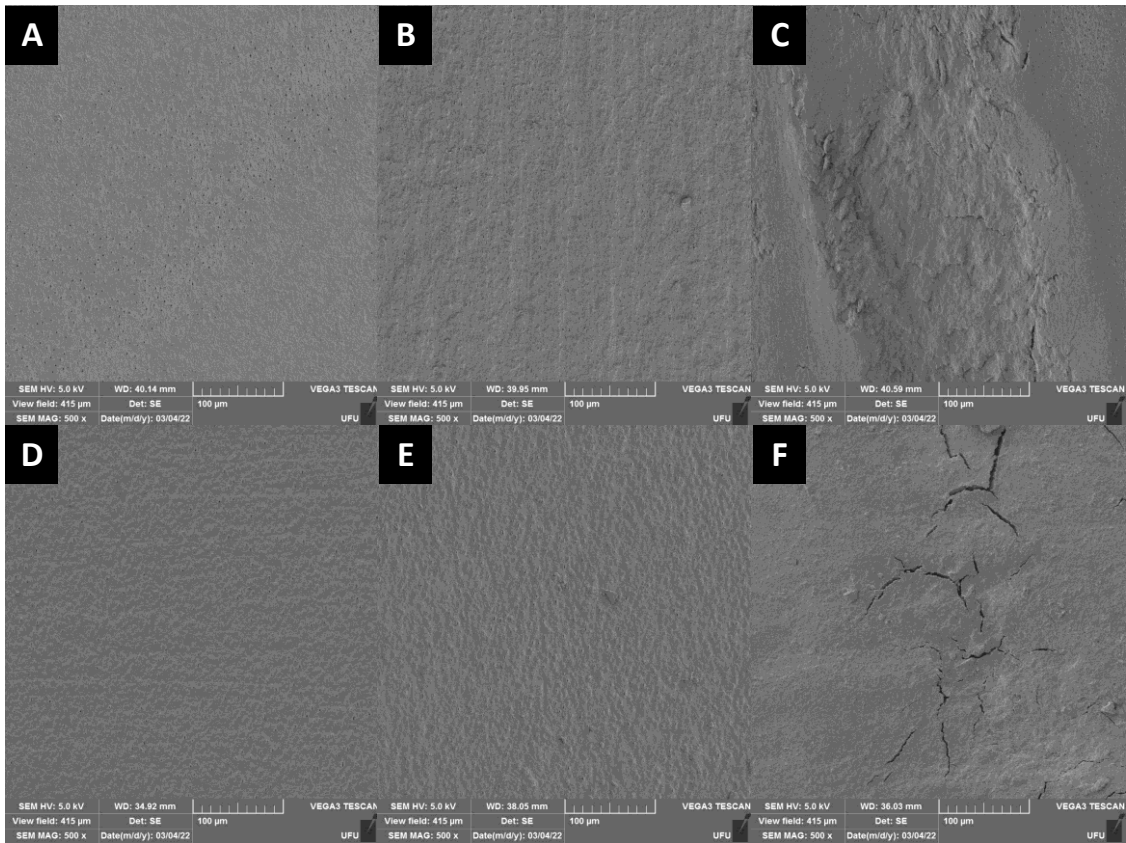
SEM images (500 x) showing the morphology of root surfaces of different interventions of Irradiated group: (A) No intervention; (B) Scaling with hand instrumentation; (C) Scaling using a ultrasonic instrumentation; (D) Prophylaxis; (E) Scaling with hand instrumentation followed by prophylaxis; (F) Scaling using a ultrasonic instrumentation followed by prophylaxis.
